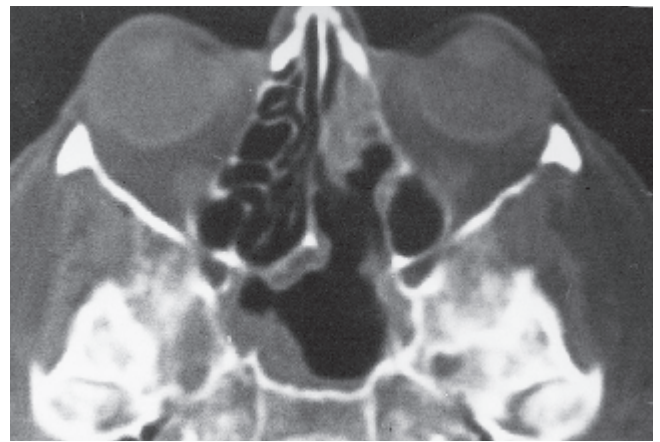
Axial CT-scan demonstrating the long-term result in a 64-year-old female patient 16 months after FESS was performed for a sphenoid sinus inverted papilloma, which mimicked an SCP. Only moderate thickening of mucosa of the sphenoid sinus and the left anterior ethmoids is present.
